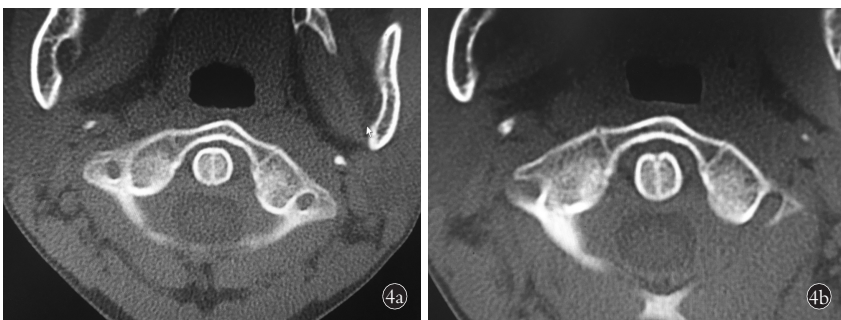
男性患者,26 岁,外伤致寰枢椎关节半脱位 4a. 治疗前 CT 示寰枢椎间隙不对称,右侧约 3 mm,左侧约 5 mm 4b. 经过 2 个疗程的牵引治疗后复查 CT 示寰枢椎间隙左右对称,疼痛缓解,活动自如
